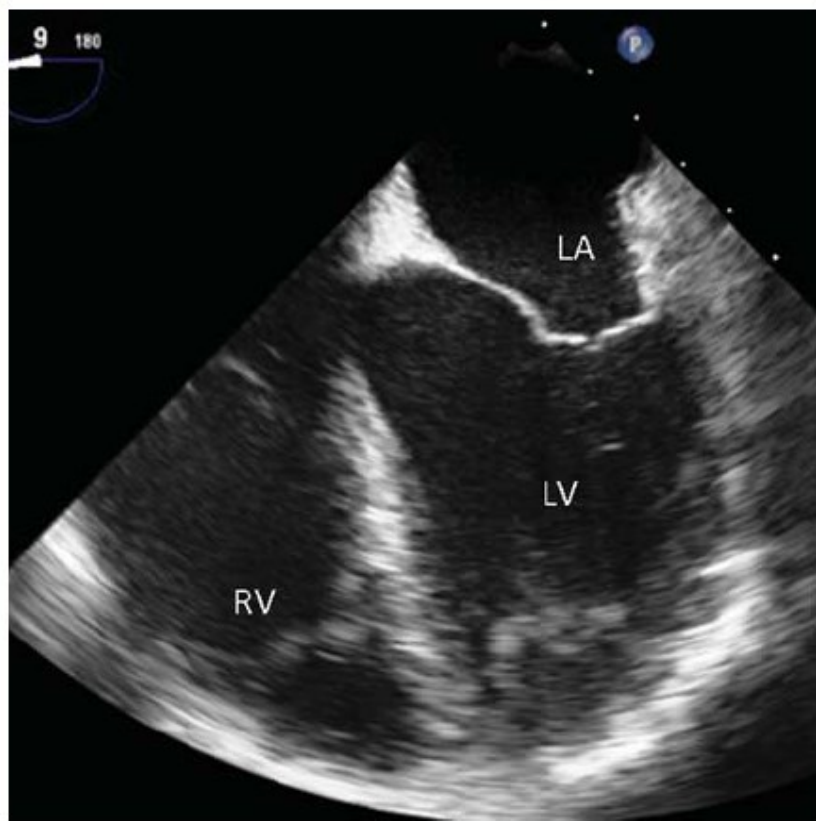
Transoesophageal four-chamber view. LA, left atrium.
